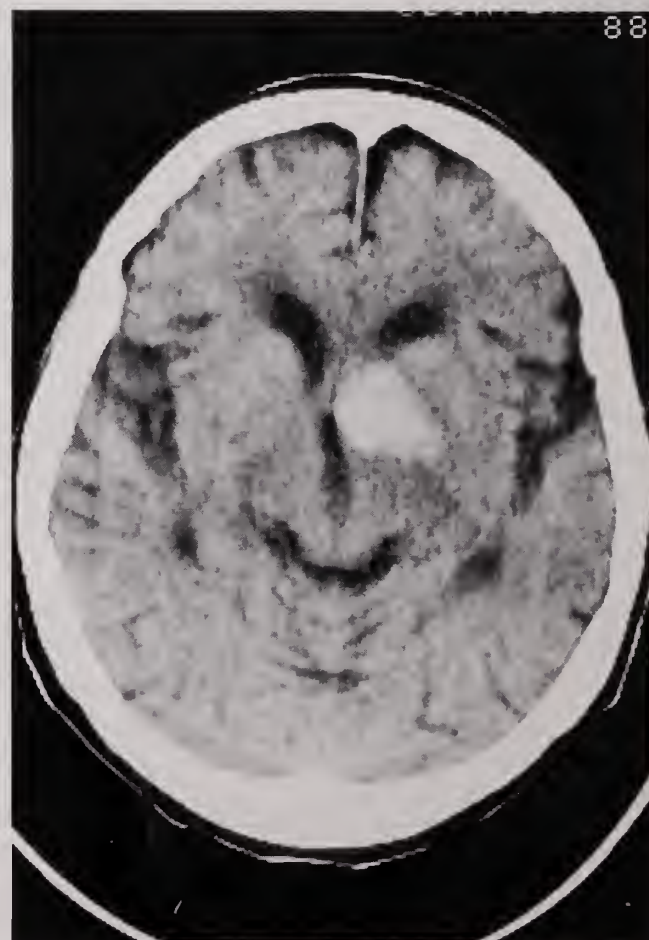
An axial CT section shows a hematoma in the basal ganglia area on the left which involves the anterior and posterior limb of the internal capsule as well as the genu. There is displacement of the anterior third ventricle across the midline.
